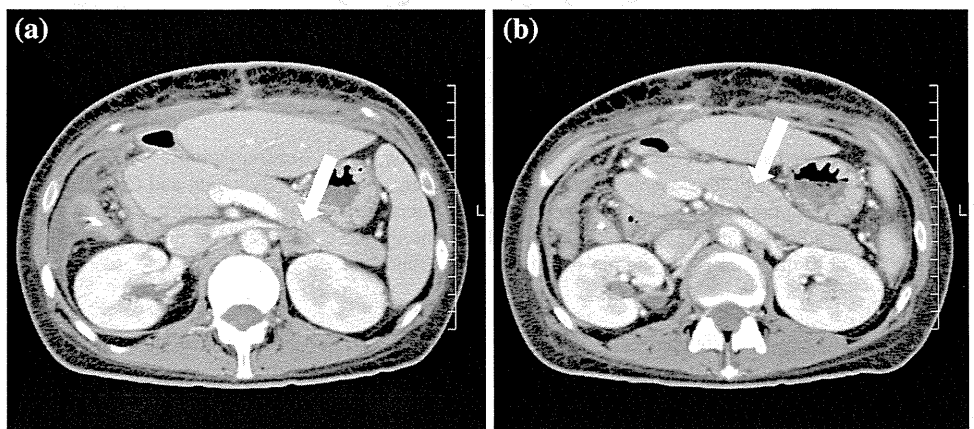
a, b Computed tomography revealed a non-enhanced tumor in the left adrenal gland and a small low-density area in the pancreatic body, indicating the recurrence of angiosarcoma
